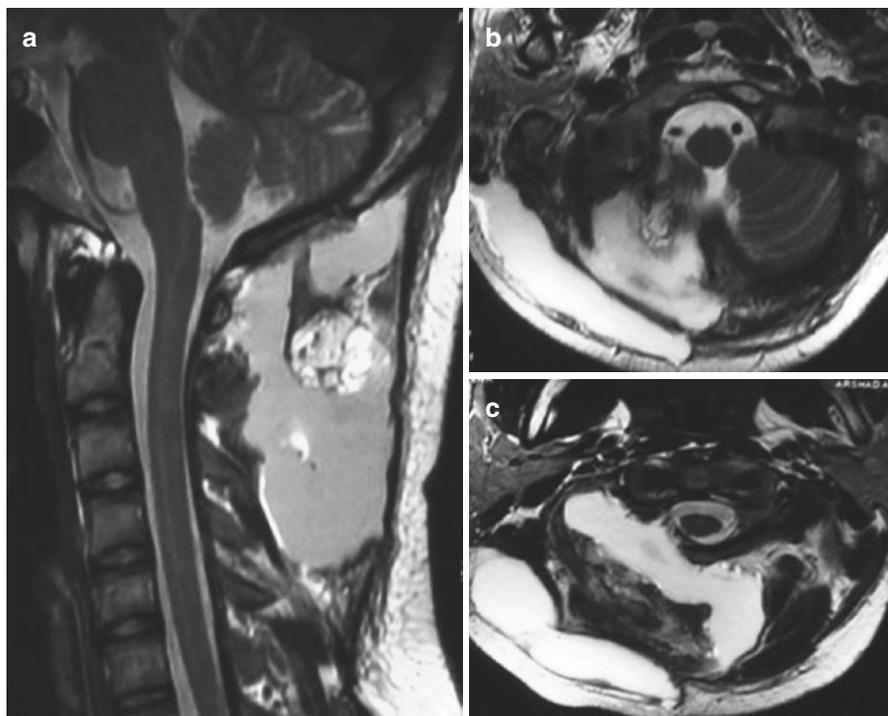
(a) Postoperative T2 sagittal and (b, c) axial MR images showing total cyst excision by the far lateral approach. (From Shukla et al. [14]; with permission)
